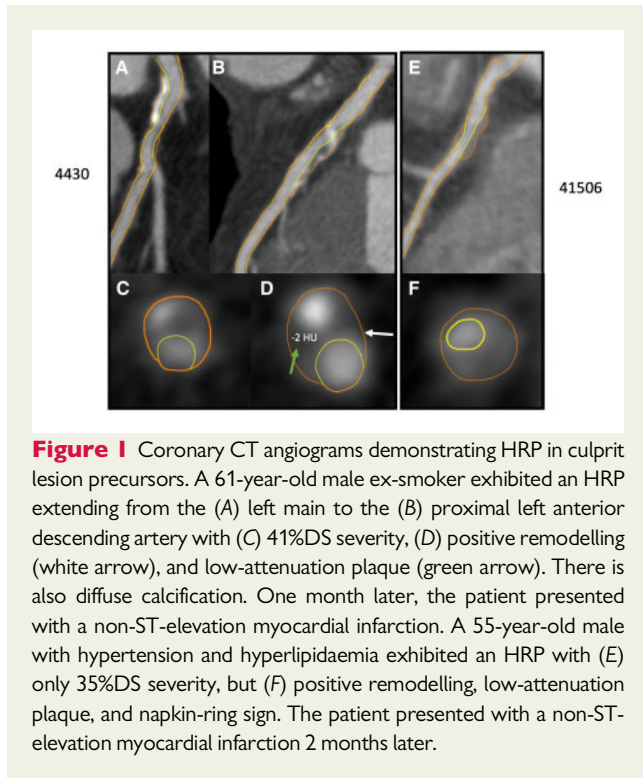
Coronary CT angiograms demonstrating HRP in culprit lesion precursors. A 61-year-old male ex-smoker exhibited an HRP extending from the (A) left main to the (B) proximal left anterior descending artery with (C) 41%DS severity, (D) positive remodelling (white arrow), and low-attenuation plaque (green arrow). There is also diffuse calcification. One month later, the patient presented with a non-ST-elevation myocardial infarction. A 55-year-old male with hypertension and hyperlipidaemia exhibited an HRP with (E) only 35%DS severity, but (F) positive remodelling, low-attenuation plaque, and napkin-ring sign. The patient presented with a non-ST-elevation myocardial infarction 2 months later.
